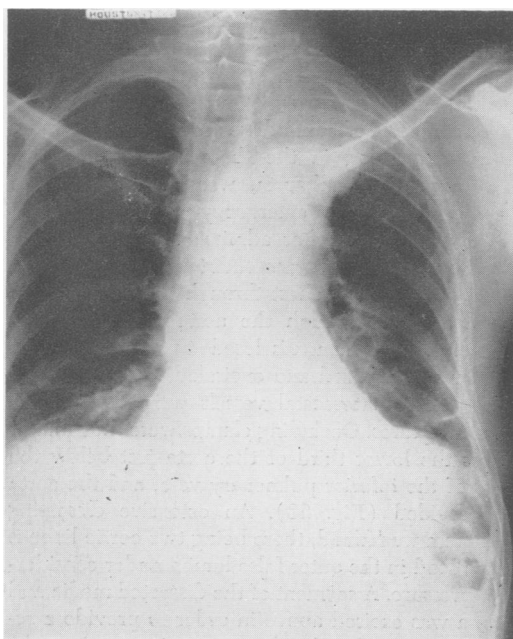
Roentgenogram of chest in Case 4, made six days after onset of symptoms, showing a mass in the left superior mediastinum confluent with the aortic shadow.
